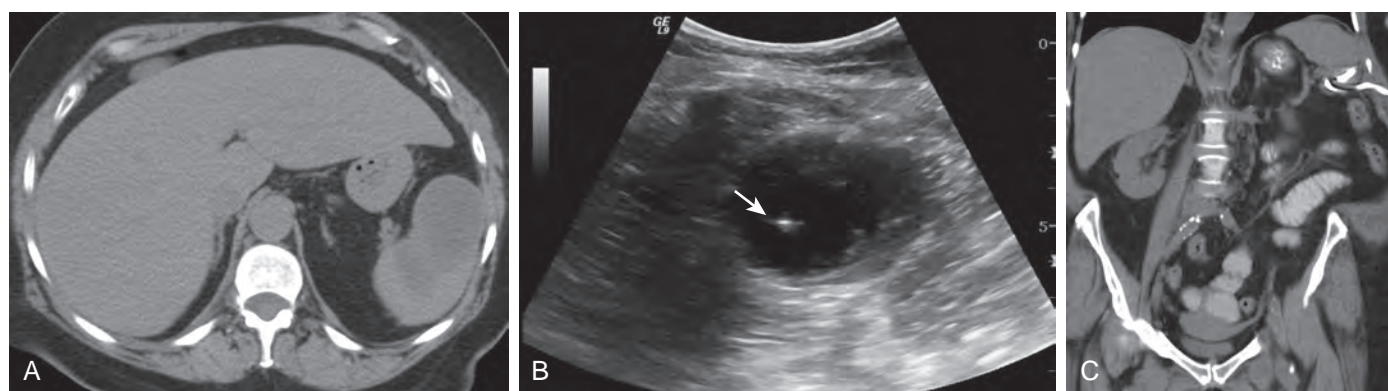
Catheter drainage of splenic abscess. A. Noncontrast CT demonstrates a focal fluid-density hypodense lesion in the splenic parenchyma. B. US revealed that the focal lesion was predominantly anechoic with dependent debris, suggesting an abscess. The echogenic needle tip is seen (arrow) within the abscess cavity. C. Follow-up CT after the procedure shows the pigtail catheter in the lower pole of the spleen with collapse of the abscess cavity.
